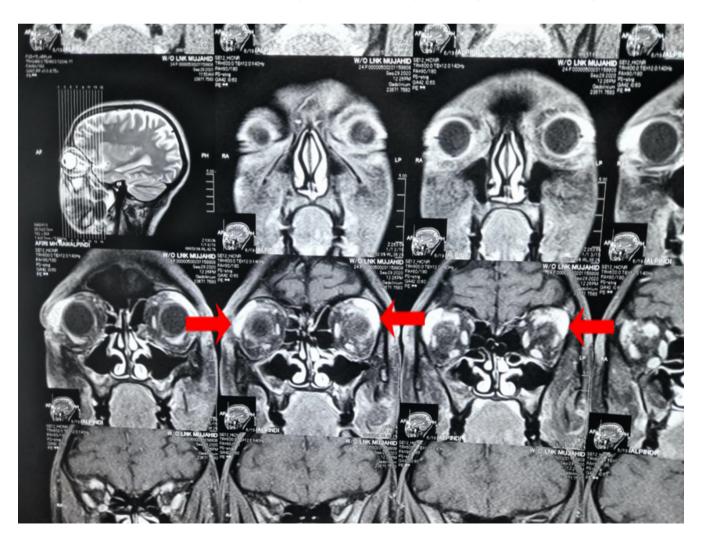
MRI of Brain and orbits of the patient prior to commencing therapy showing lacrimal gland enlargement.
